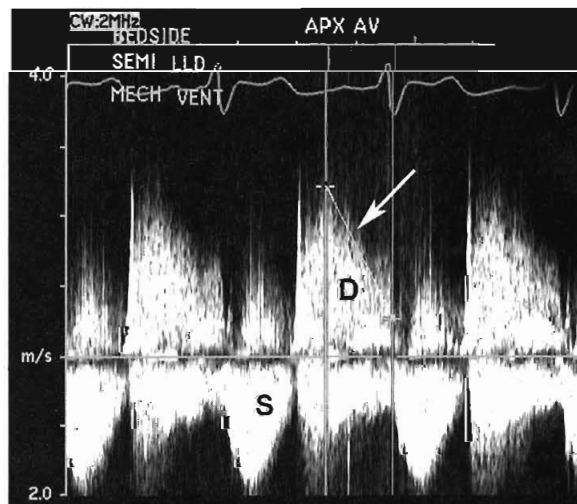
In the same patient as Figure 103-5, continuous wave Doppler flow of the flow across the aortic valve shows an increased antegrade velocity in systole (S) consistent with a high transaortic stroke volume. In diastole (D), a dense signal of retrograde flow is seen with a steep deceleration slope (arrow) consistent with equalization of pressures between the aorta and left ventricle in diastole.
